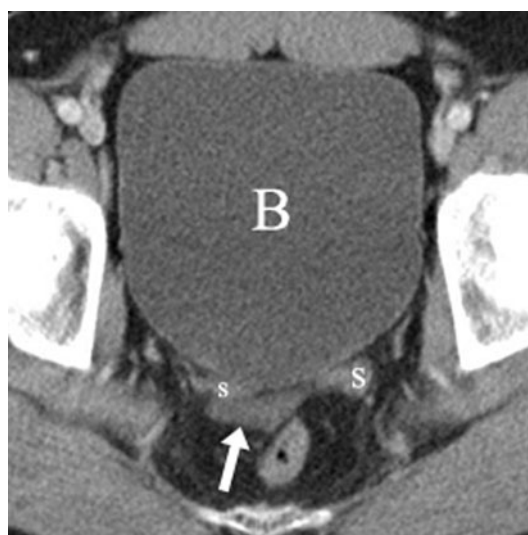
A 28-year-old male status post-blunt abdominal trauma. Contrast-enhanced CT of the pelvis demonstrated a small amount of free fluid (*arrow*) posterior to the seminal vesicles (*S*). Bladder (*B*) is noted. Surgery was not performed. Chart review revealed that the patient did not present with bowel and/or mesenteric injury during the 2 weeks of clinical follow-up.
